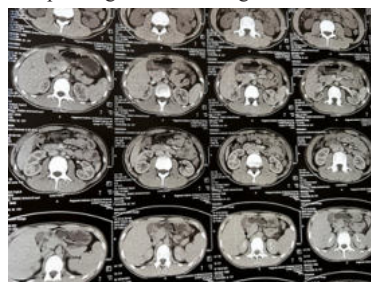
CT uogram showed normal PCS anatomy of both the kidneys with no evidence of hydroureteronephrosis or any scarring and feats of reactive pyeloureteritis.
